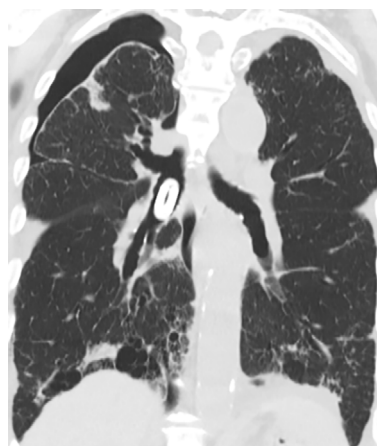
A coronal section of a computed tomography scan showing that the capsule is located in the bronchus intermedius and right pneumothorax.
